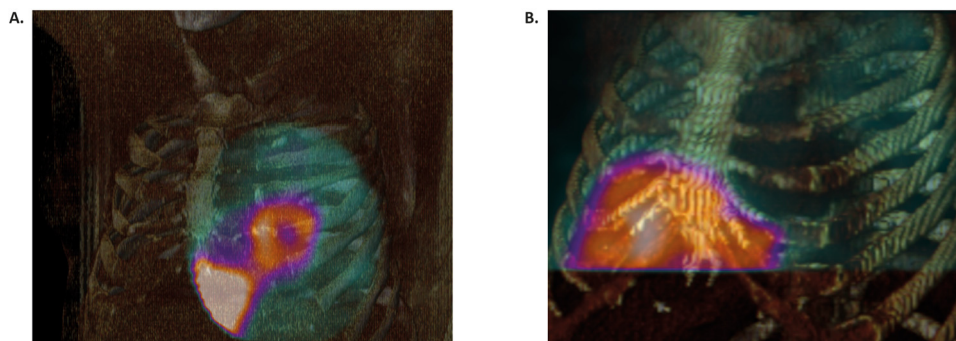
Uptake of [^{123}I]-mIBG on SPECT. The uptake of [^{123}I]-mIBG on SPECT in two patients Figure 6.A shows a patient without cardiac denervation. The heart/mediastinum ratio is 2 (normal value: 1.79 +/- 0.22) Figure 6.B shows a patient with cardiac denervation. The heart/mediastinum ratio is 1.08.
